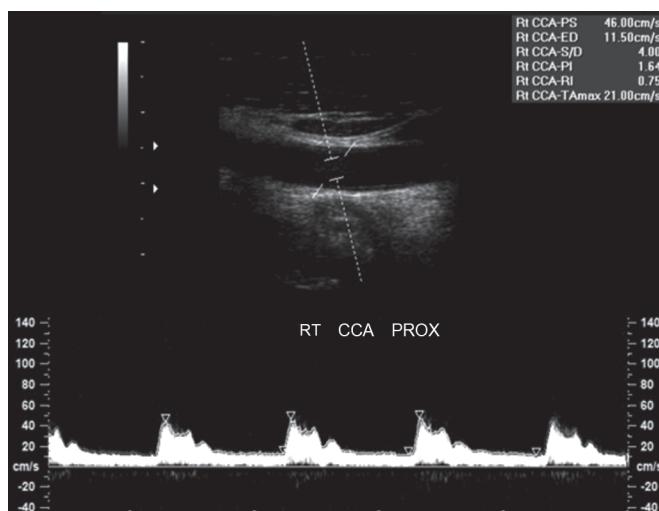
Doppler spectral display
